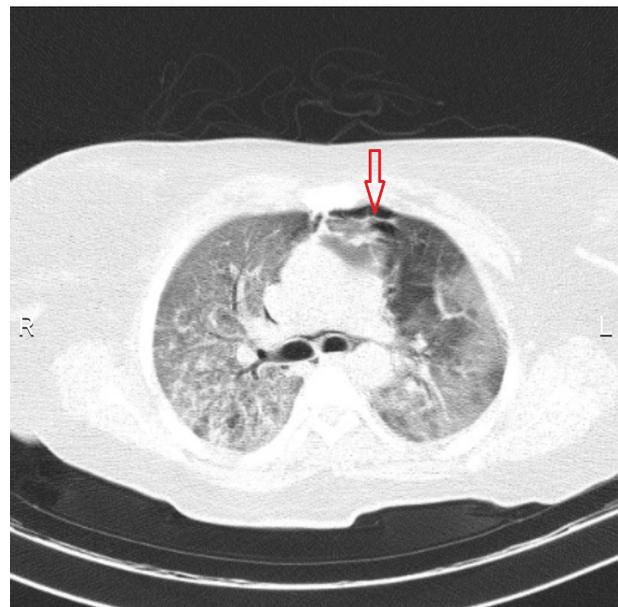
Pneumomediastinum in the chest CT scan.
